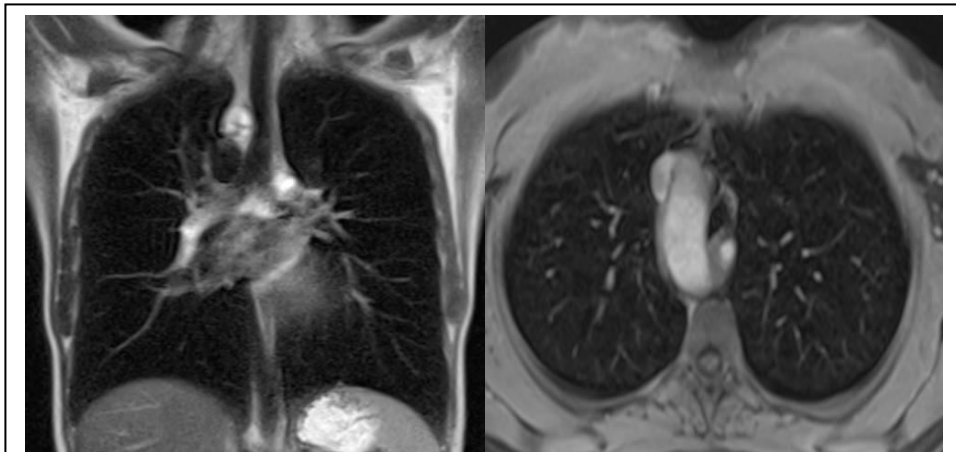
Thoracic MRI images showing the right sided arcus aorta and tracheal compression (patient in 5th figure).
